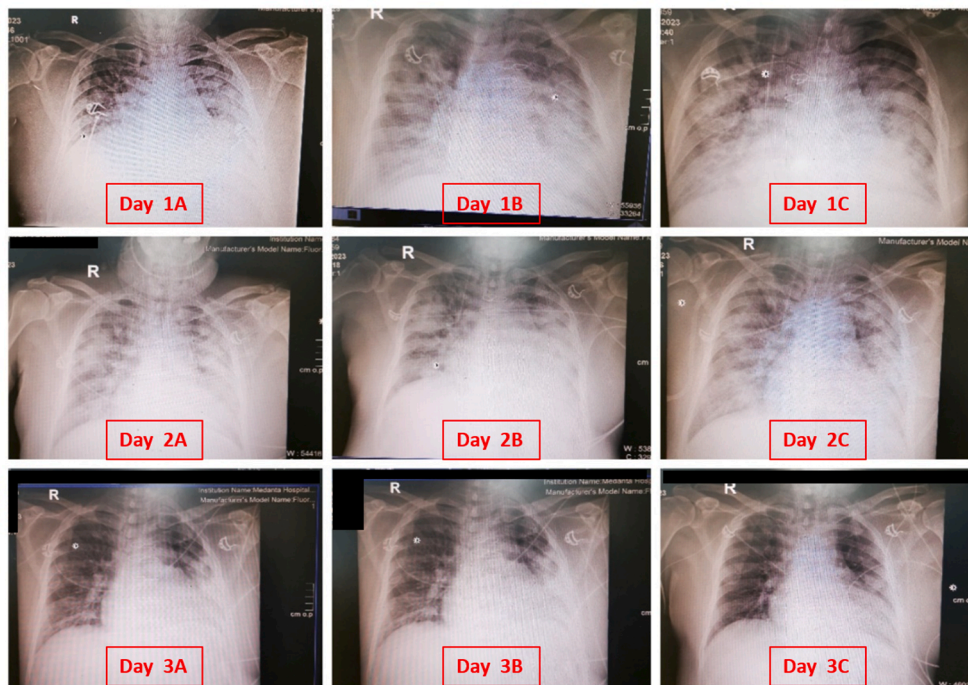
Consecutive x-rays of case 3 starting from day 1 showing progressive clearance over 3 days of therapy.
